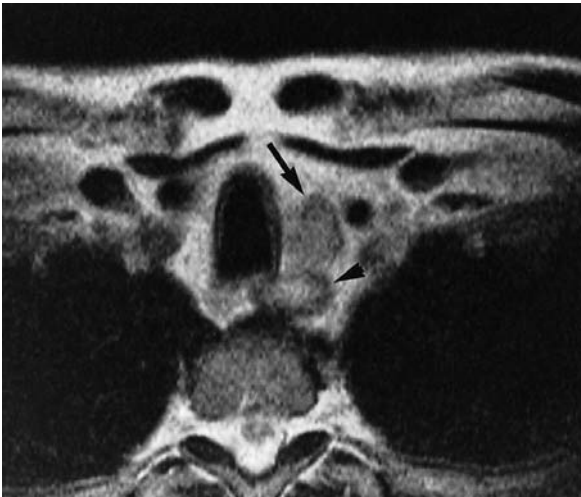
Pathological tissue (*arrow*) in the left paratracheal space after thyroidectomy and two-fold RIT with normal post-therapeutic RI scan and recent negative serum TG. In the T2-TSE sequence, the lesion seems to be distinguishable from the oesophagus (*arrow-head*). ^{99m}Tc -sestamibi was equivocal, but ^{18}F FDG-PET was positive. Surgery yielded the diagnosis of oesophageal cancer
